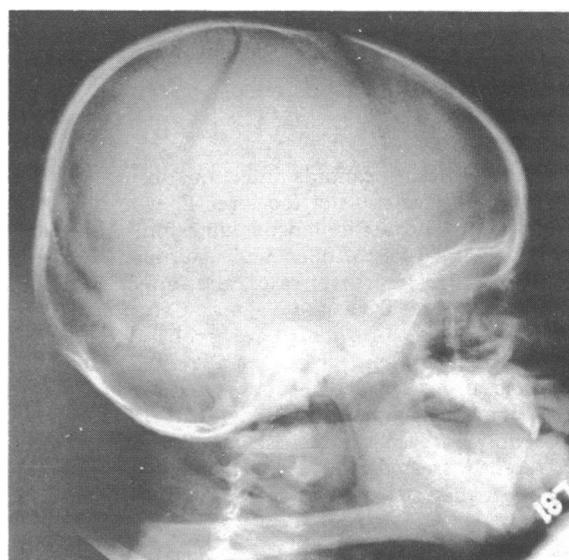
X-ray picture of skull at time of first admission.
